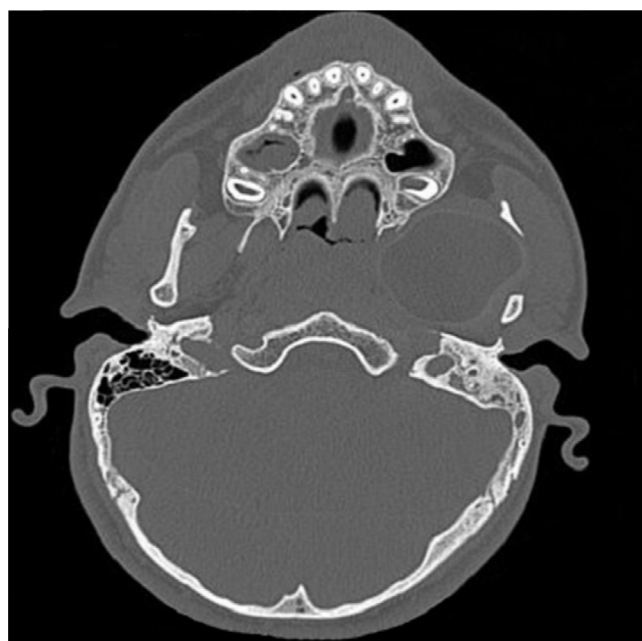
The axial CT scan. The cystic lesion compressed the left mandibular ramus and zygomatic arch laterally.
